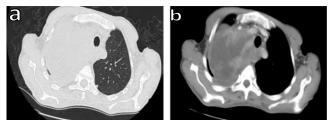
Thoracic CT scan in the parenchymal window (a) and mediastinal window (b) revealed a right mediastinal-pulmonary tumor mass measuring 120×66 mm, in close contact with the trachea, esophagus, and thyroid
